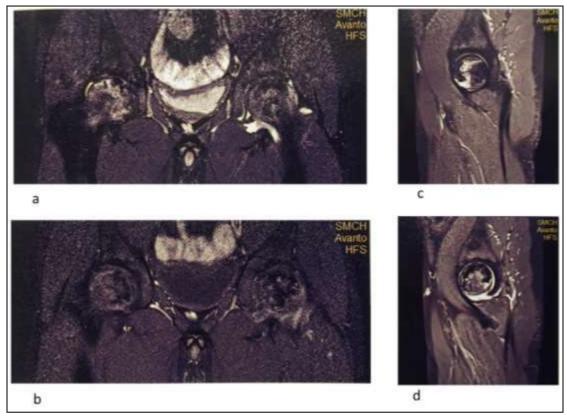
Osteonecrosis of hip. MRI PDFS Coronal (a), Post-contrast Coronal (b), STIR right hip(c), Left hip (d).
